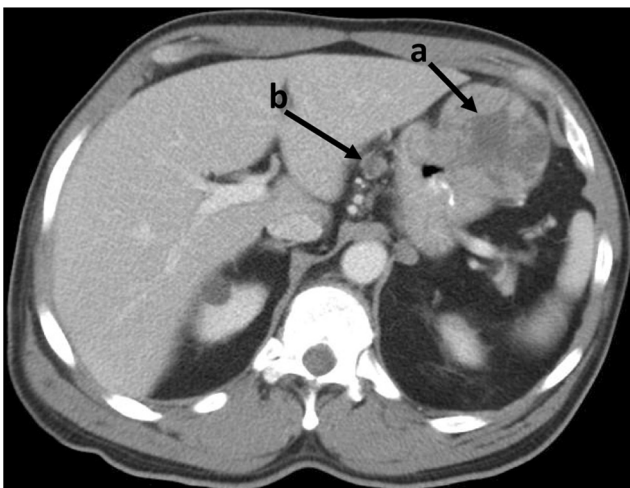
Pre-surgery CT (*a* primary tumor in body of stomach; *b* enlarged, necrotic perigastric lymph node)
